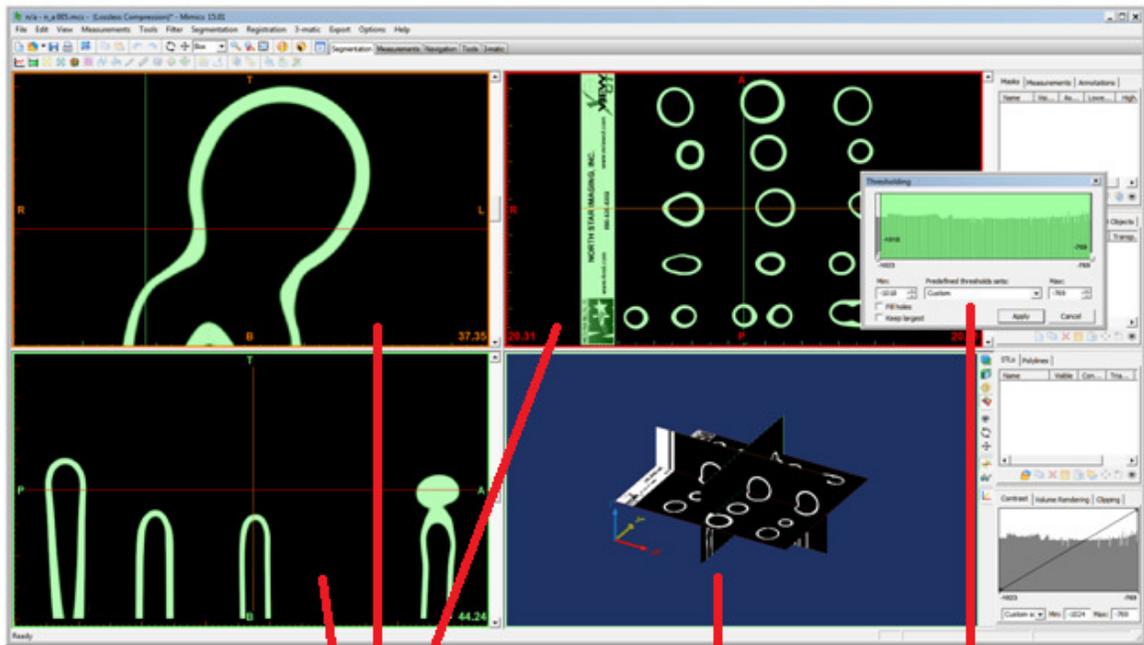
When the stack of images from a CT or MRI scan is imported into Mimics, the user is prompted to confirm the orientation of the scanned object by identifying the anterior (A), posterior (P), left (L), right (R), top (T), and bottom (B) orientations.
